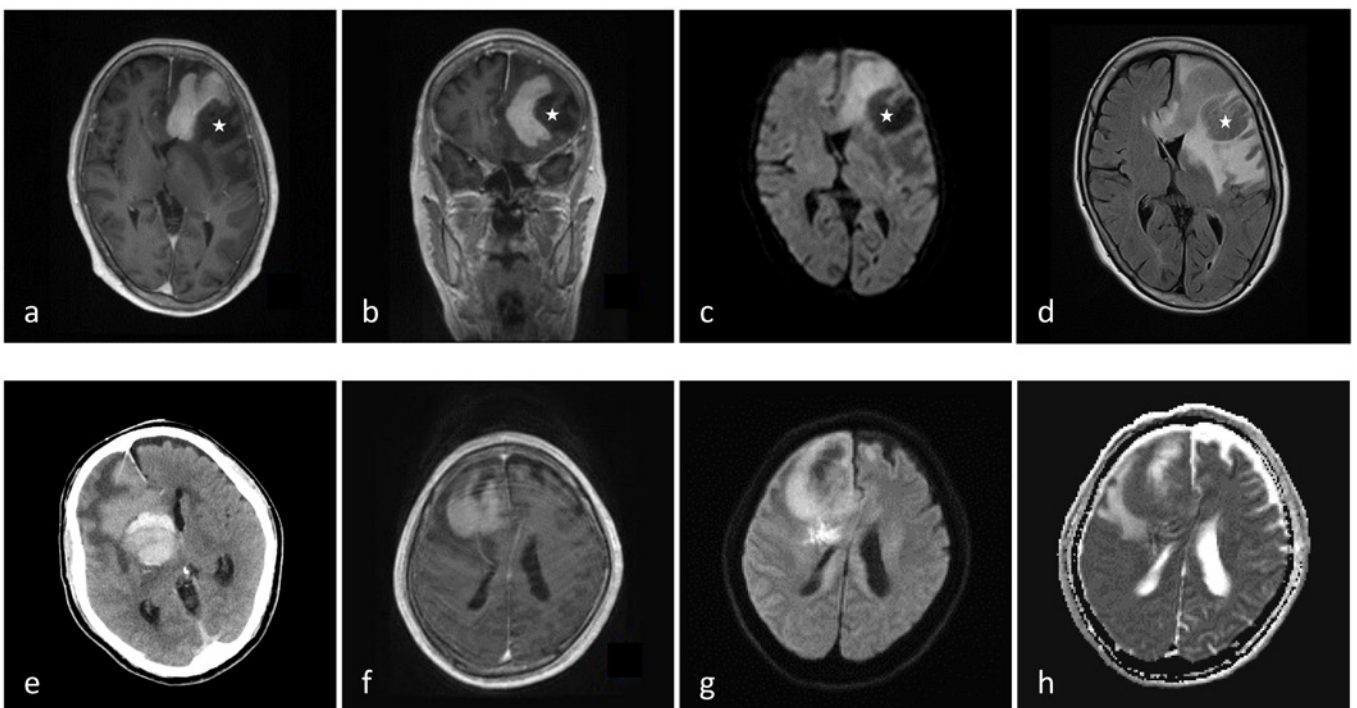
Imaging studies of PCNS-DLBCL. (a to d) MRI of case 1. Transverse (a) and coronal (b) sections of contrast-enhanced T1-weighted images; DWI (c); and T2 FLAIR image (d). The circular area indicated by asterisks was considered to represent necrotic tissues. (e to h) CT and MRI of case 2. Contrast-enhanced CT image (e); contrast-enhanced T1-weighted MRI (f); DWI (g); and ADC image (h).
